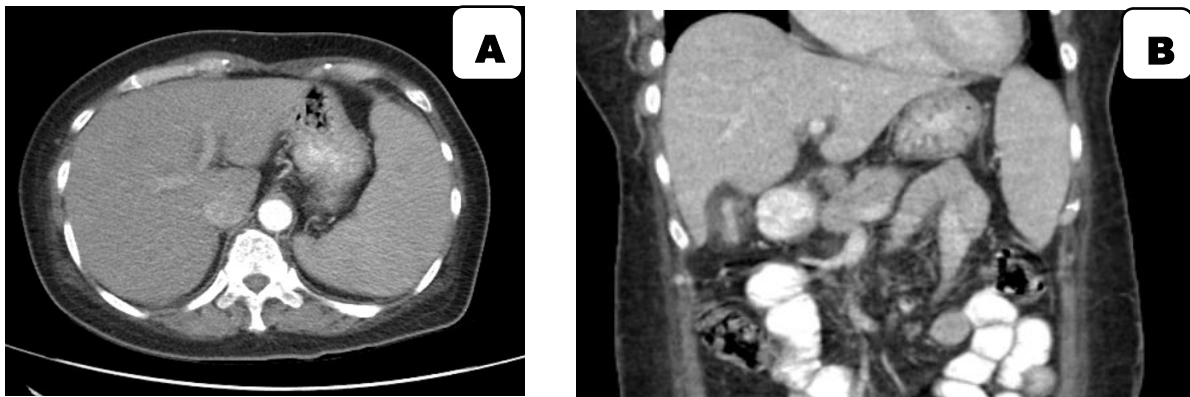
(Abdominal CT-Scan imaging of a patient with acute hepatitis B. A: Axial Abdominal CT-Scan; B: Coronal Abdominal CT-Scan.)
